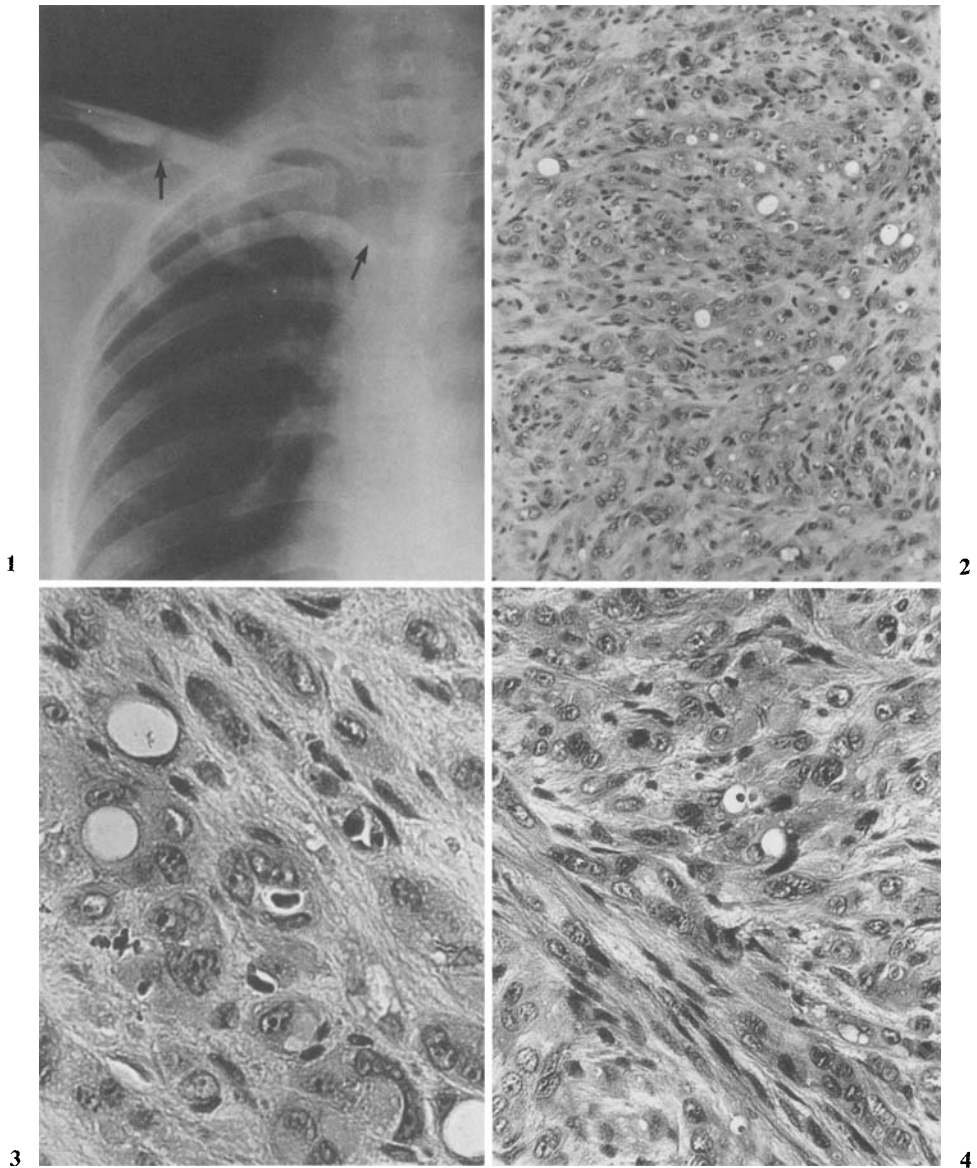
Radiograph showing destructive change of vertebral (Th3) bone and osteolytic lesion of right clavicular bone (*arrows*)
